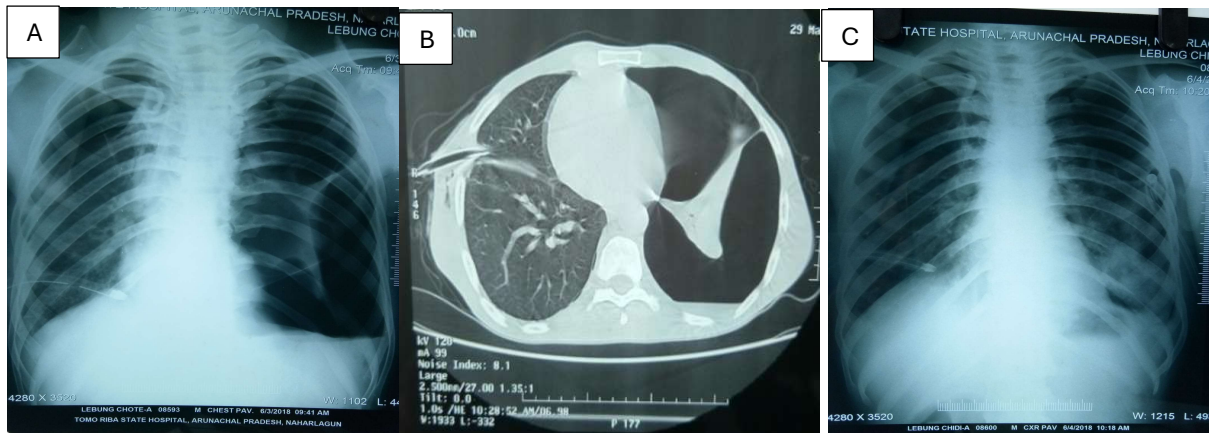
[A]: Chest X-ray (PA) showing re-expansion of right lung, [B]: CT Thorax showing massive left pneumothorax with ICD tube in right, and [C]: Chest X-Ray showing B/L lung expansion with ICD in situ.
